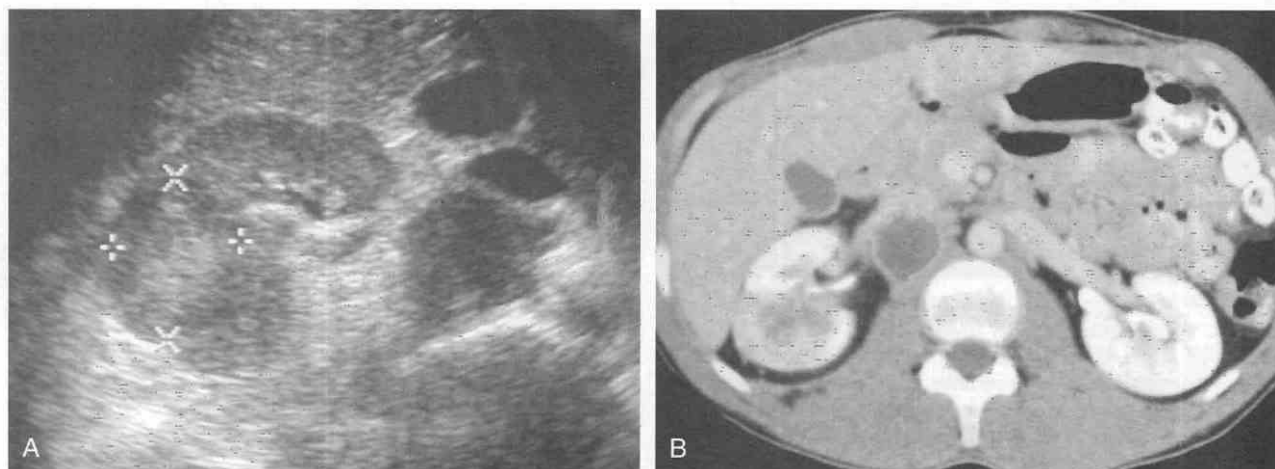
Medullary carcinoma. Transverse oblique view (*A*) of right kidney shows an upper pole hyperechoic mass. (*B*) Contrast-enhanced axial CT shows heterogeneous enhancement of mass. (Courtesy of Pickhardt PJ: Abdominal Imaging, 1998.)
